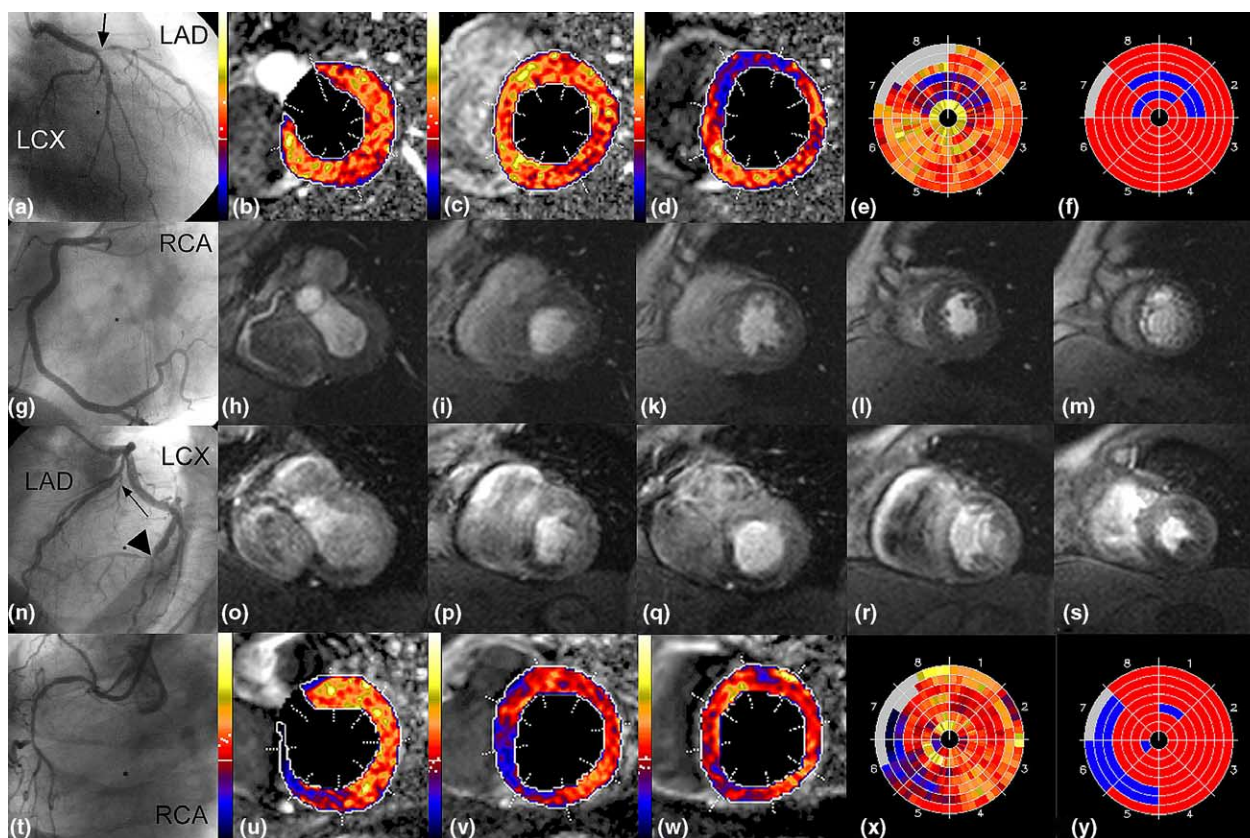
Examples of MR perfusion studies for dose 1 (top rows a–m) and dose 3 (bottom rows n–y). For dose 1, a stenosis in the left anterior descending coronary artery (LAD) is shown on X-ray angiography (arrow in a) with 5 short-axis MR perfusion images at peak bolus effect in h–m demonstrating low signal areas in the anterior wall (k–l). Corresponding upslope maps are shown in b–d and polar maps for the subendocardial layer are given with thresholds applied pixel-wise (e) and for entire segments (f) with blue/red encoding for upslope values below/above the thresholds, respectively (the polar maps show all acquired slices, for ROC analyses only the central 5 slices were used, for reasons see text). For dose 3, stenoses in the small first diagonal branch of the LAD (arrow in n) and the large left circumflex coronary artery (LCX) are shown (arrowhead in n). For dose 1, note the considerable noise and reduced dynamic range of signal response (h–m) compared with dose 3 (o–s). Upslope maps and subendocardial polar maps for dose 3 (u–y) are generated as explained for dose 1. The second patient (dose 3) further demonstrates the limitation of using coronary anatomy as a reference for perfusion studies: perfusion defects in segment 5 and 6 represent a mismatch with the right coronary artery territory in this patient with a stenosis in the large LCX.
